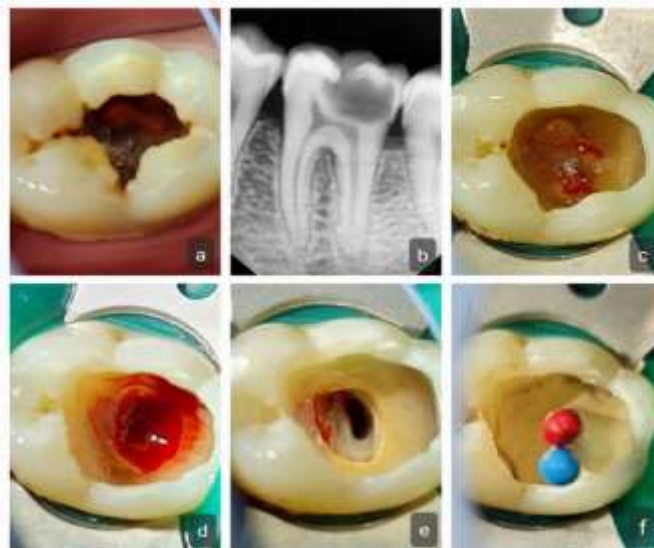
(a and b) Pre-operative clinical and radiographic image of 36. (c) Pulp exposure during caries excavation. (d) Continuous bleeding even after application of NaOCl (Distal Canal). (e) Pulp extirpation from the distal canal. (f) Canal projection using GP cones and Biodentine placement.
